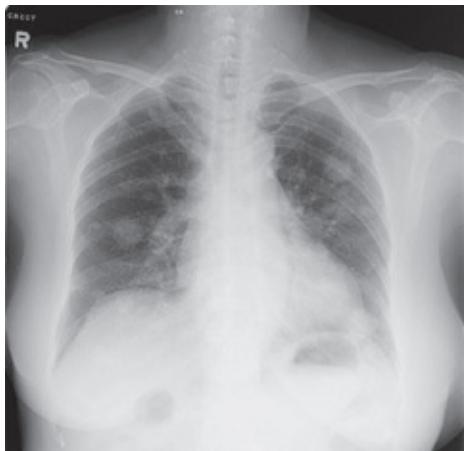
Chest radiograph on presentation 2010
